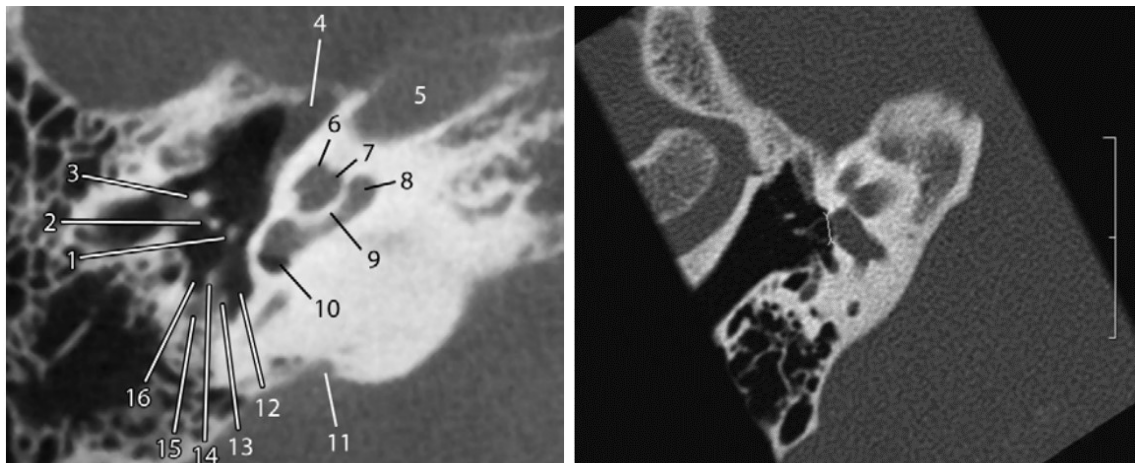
Figure C-3: Resolution of current imaging technologies. (left) shows an image collected with MR by Juliano et al (2013) with feature '2' indicating the stapes; (right) shows a high-resolution CT image collected by Rousset et al (2014)
